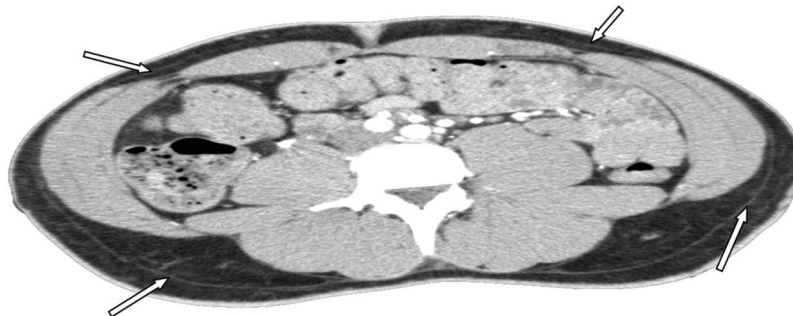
On abdominal CT scan images, the SLAS is presented as a circumferential layer extending all the way to the spinous process adhesion line posteriorly: underlying Scarpa's fascia, overlying the anterior rectus sheath medially, and external oblique fascia laterally. The arrows indicate Scarpa's fascia.
